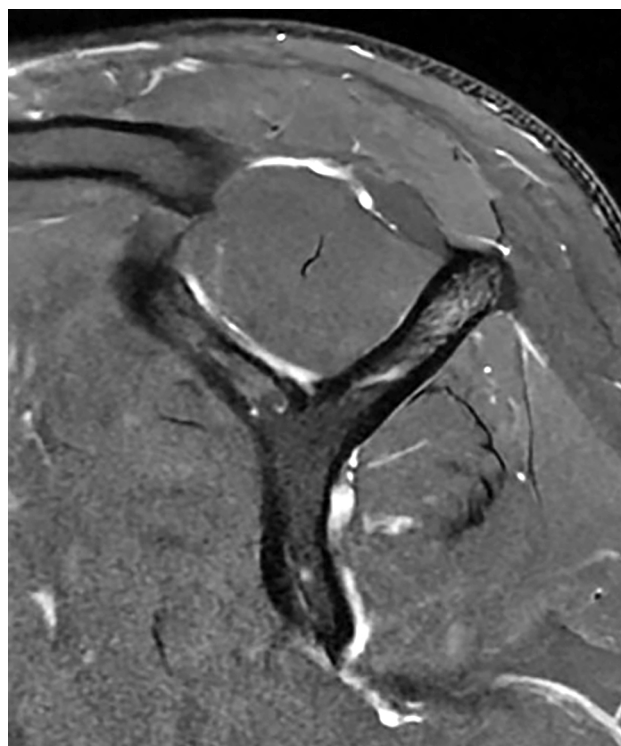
Example of negative tangent sign on T2-weighted fat-saturated sagittal cut on magnetic resonance imaging.
